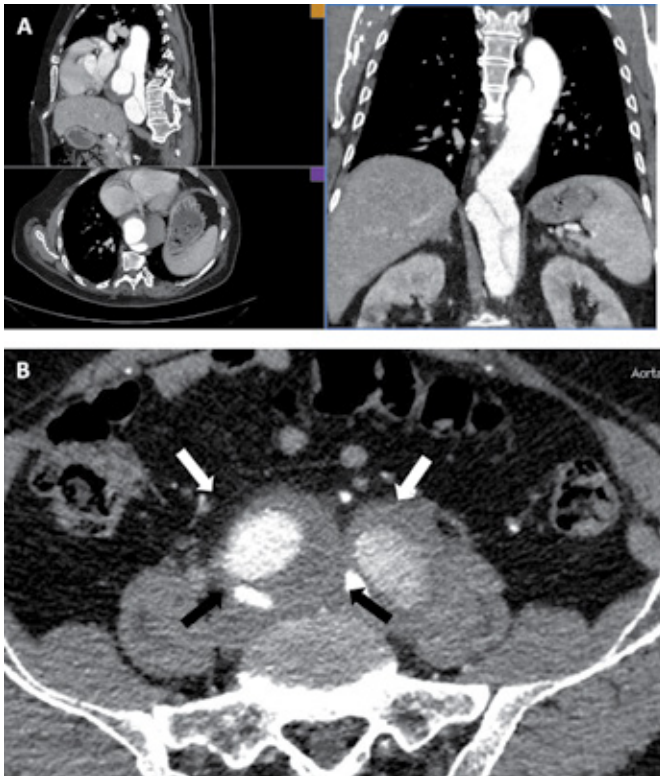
(A) CTA showing a type B aortic dissection with the entry tear located 7.5 cm below the left subclavian artery. The diameter of the descending thoracic aorta at the widest point was 75 mm. (B) at the level of the common iliac arteries there were two narrow true lumens supplying the internal iliac arteries (black arrows) and two dilated false lumens supplying the external iliac arteries (white arrows). The diameter of the right CIA was 5 cm and of the left 4.4 cm.
